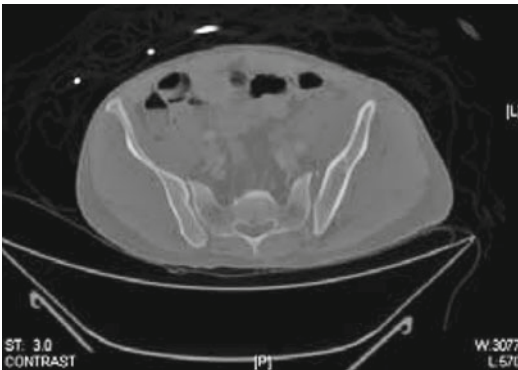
CT scan demonstrating left sacroiliac joint widening
